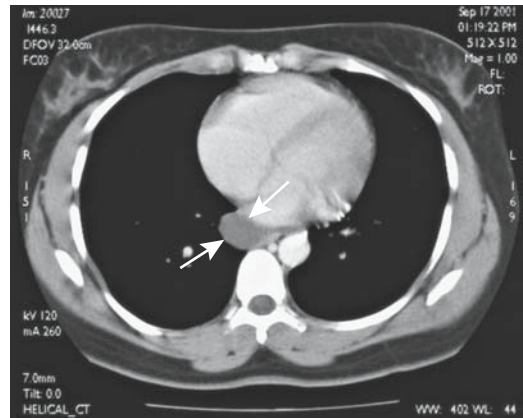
Esophageal duplication. Computed tomography (CT) reveals a cyst (arrow) adjacent to the distal esophagus. It did not communicate with the esophageal lumen. (Courtesy of Temil Tirkes, M.D., University of Pennsylvania.)
